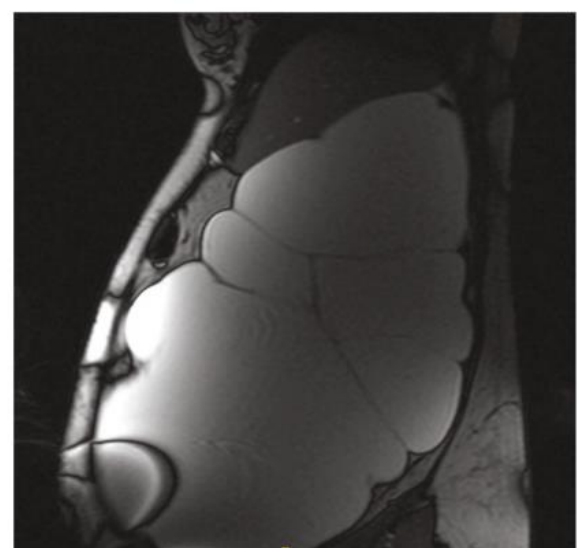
MRI T2 image sagittal view of the abdomen and pelvis.
